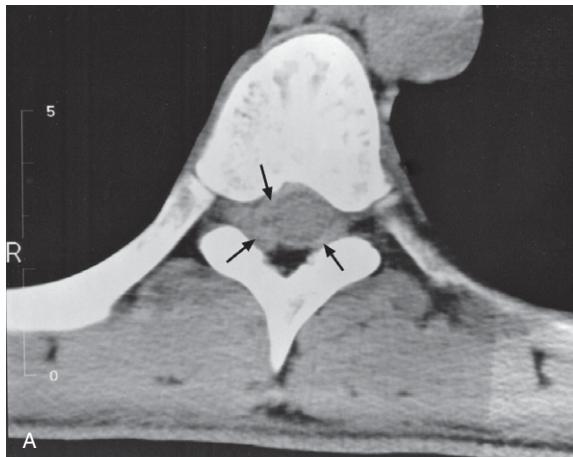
(A and B) Thoracic spine CT axial images showing the abnormal increased soft tissue (arrows) in the epidural fat outside the thecal sac, more prominent to the right side.
